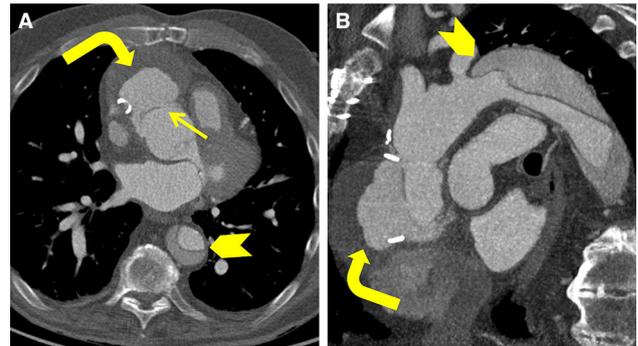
Dehiscence following ascending aorta repair with acute type B aortic dissection. a Axial-gated CTA image demonstrates dehiscence along the ascending aorta anastomosis with a focal defect (straight arrow) and extraluminal contrast (curved arrow). An acute type B aortic dissection is present in the DTA (arrowhead). b Sagittal oblique MIP reformat demonstrates the collection of extraluminal contrast (curved arrow) and acute type B dissection arising distal to the left subclavian artery
